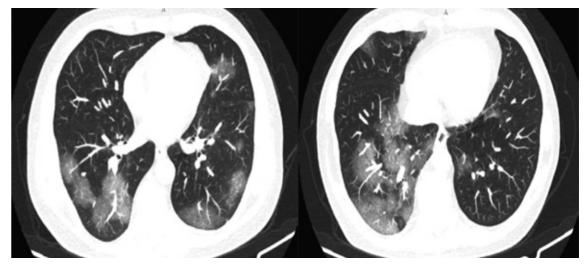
GGO with/ without consolidation and dilated vascular markings on CT.
